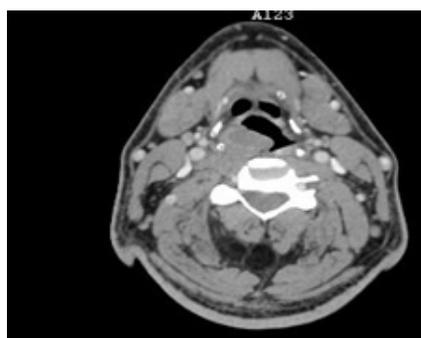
Preoperative CT Neck.
